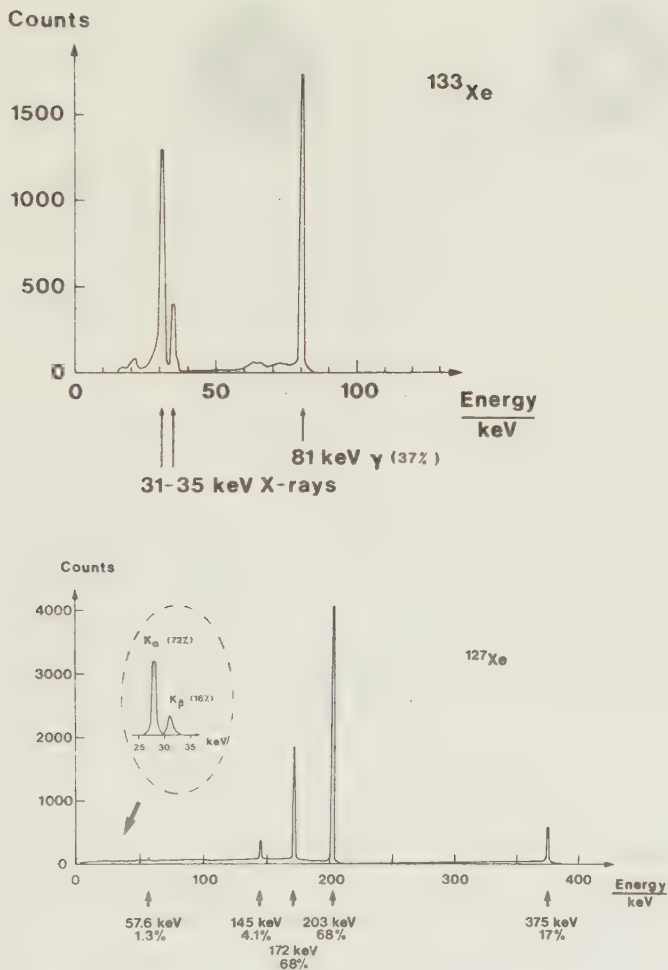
Pulse-height distributions of the photon emission from Xe-133 (top) and Xe-127 (below). An intrinsic Ge-detector was used to measure Xe-133 and the characteristic X-ray emission (iodine) from the decay of Xe-127. The gamma-radiation from Xe-127 was measured with a Ge(Li)-detector.
